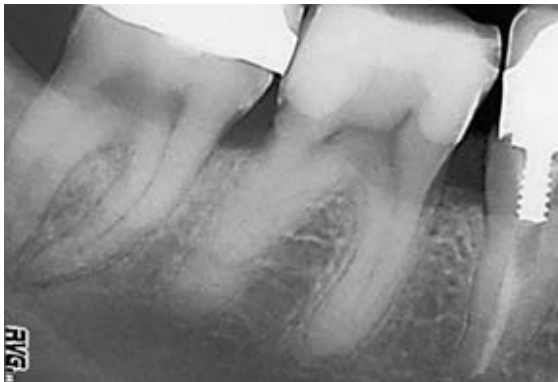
Radiograph of region 47 to 45.
